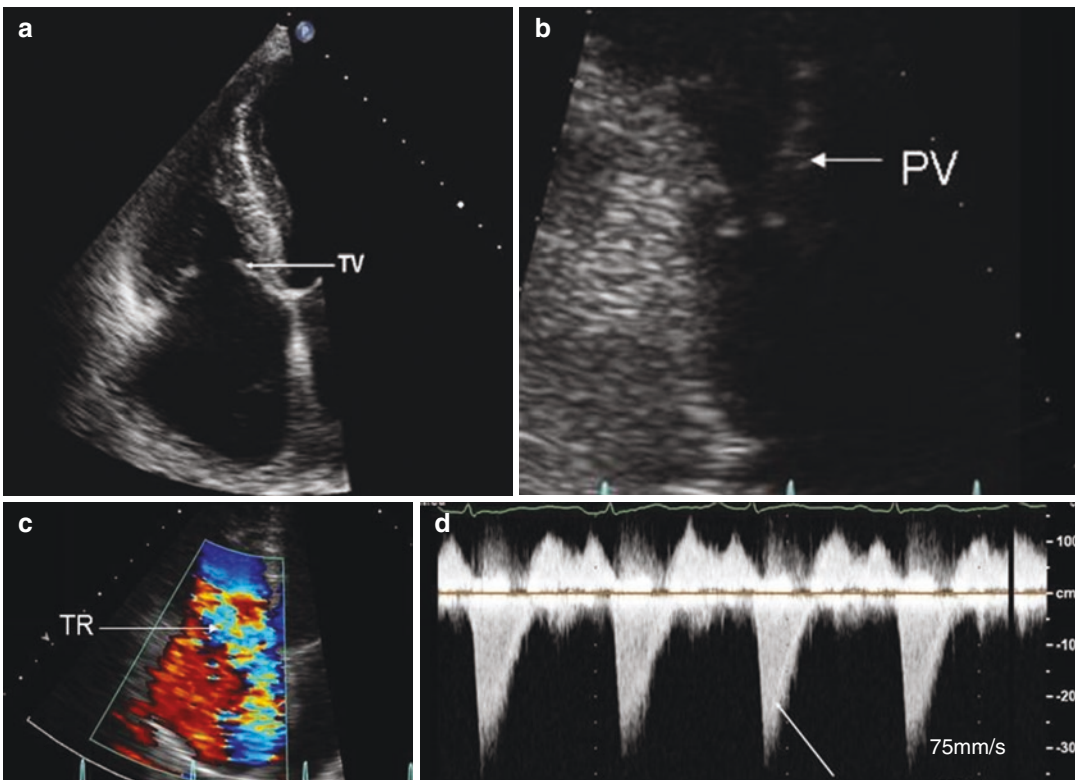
2D echocardiogram in carcinoid heart disease. (a) Thickened, retracted, fixed tricuspid valve (TV) leaflets which do not co-apt. (b) Thickened, fixed and retracted pulmonary valve (PV) cusps. (c) Color Doppler
